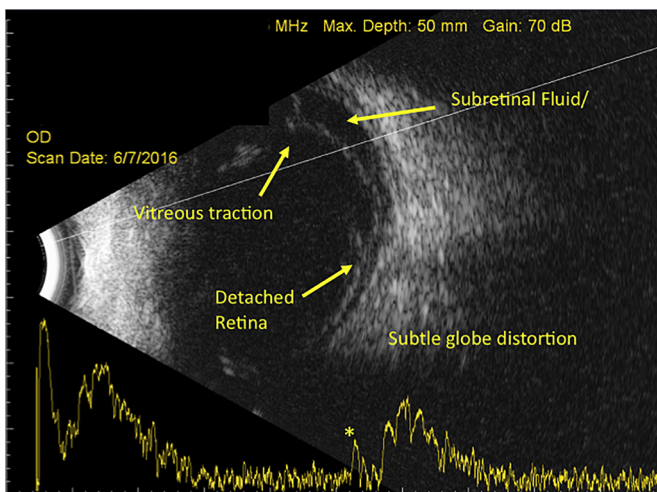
B-scan ultrasound of an Ebola virus disease (EVD) survivor with a traction retinal detachment. A B-scan ultrasound of an EVD survivor with a gain of 70 dB shows vitreous traction with concomitant retinal detachment and subretinal fluid involving the macula, which is confirmed by the high-frequency spike on the A-scan (yellow asterisk). There is subtle globe distortion indicative of early phthisis bulbi (cosmetic deformity of globe due to chronic low intraocular pressure). EVICT protocol enrolment and surgery were deferred owing to poor visual prognosis.
